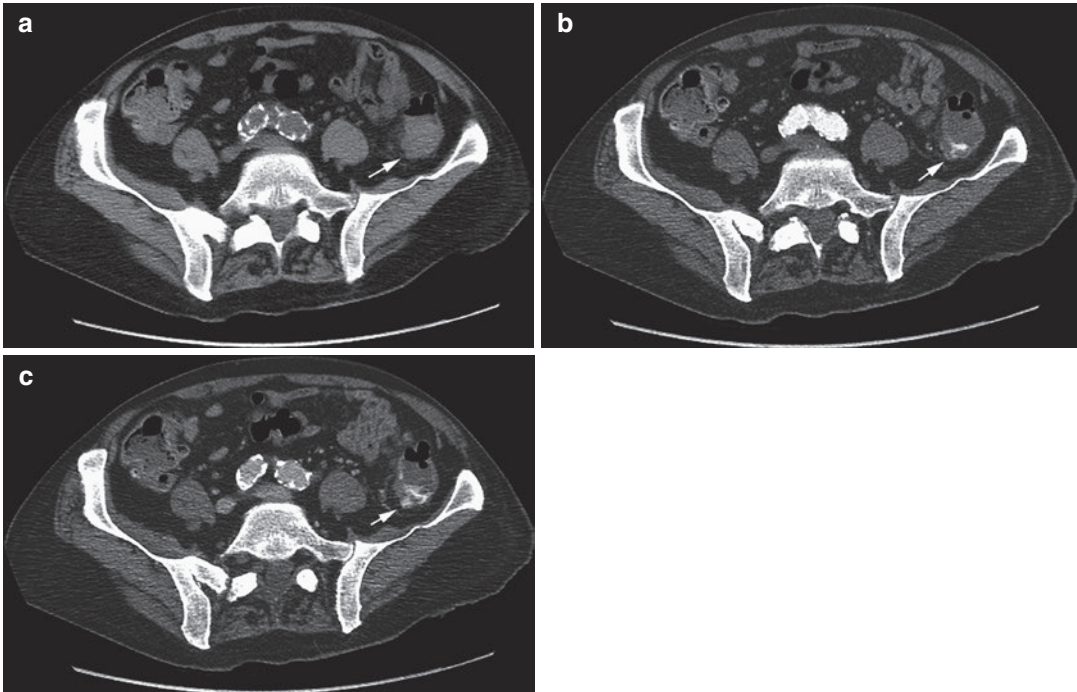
A 78-year-old presents to the ER with lower gastrointestinal bleeding. (a) Axial non-contrast CT shows no acute abnormality. (b) Arterial phase shows contrast pooling within the distal descending colon (*arrow*). (c)
